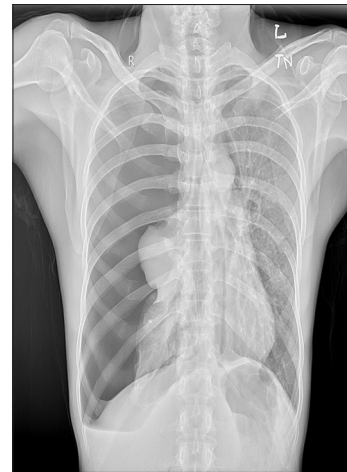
X-ray chest showing significant right-sided hydropneumothorax with associated collapse of the right lung
